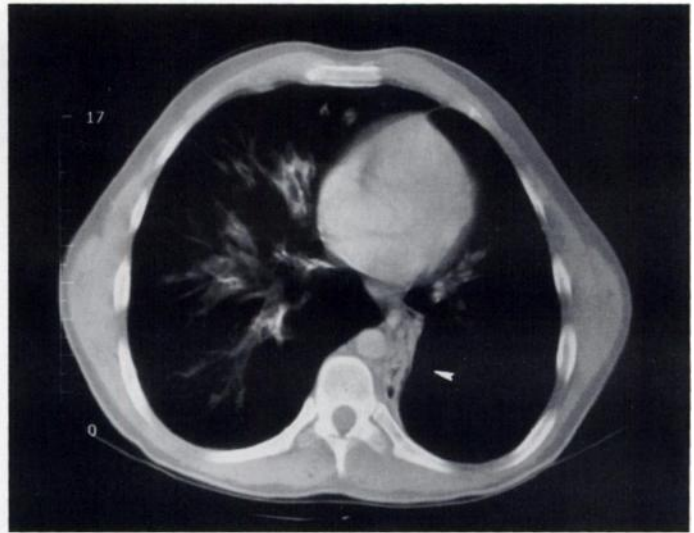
Chest CT confirms left lower lobe collapse (arrow) with oligemia of the overinflated left upper lobe.
